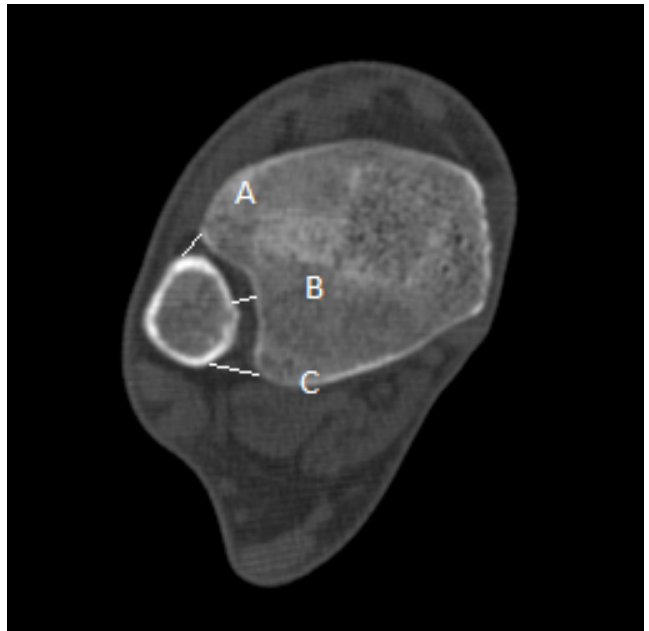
Axial CT scan with measurements (A=anterior, B=central, C=posterior)
